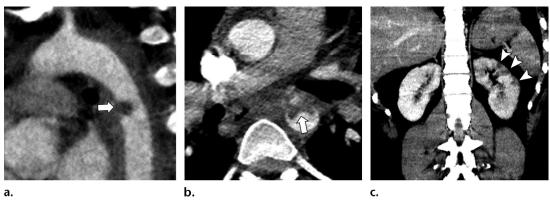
Downstream emboli with MAI in a 14-year-old girl who was an unrestrained driver in a motor vehicle collision. (a, b) Sagittal (a) and axial (b) multidetector CT angiograms show an isthmic MAI manifesting as an intraluminal thrombus (arrow). (c) Coronal multidetector CT angiogram obtained through the abdomen shows multiple small left renal infarcts (arrowheads). The results of laboratory tests showed no associated renal dysfunction.
